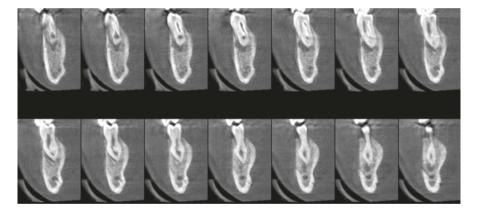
This is a small-field-of-view cone beam computed tomography scan of the first lefthand-side mandibular premolar which shows a dens invaginatus. It can be appreciated that there is already a periapical infection present and that the endodontic treatment will be complicated due to the complexity of the pulp system An attempt to classify dens invaginatus was first proposed by Hallett (1953). The first three types in Hallett's classification refer to crown invaginations. However, all crown invaginations were designated as type 1 in a classification system put forward by Oehlers (1957). Other classifications have also been described by Ulmansky and Hermel (1964), Schulze and Brand (1972), Vincent-Townend (1974), Parnell and Wilcox (1978), and Hicks and Flaitz (1985). The broad classification put forward by Schulze and Brand (1972) includes 12 variations, starting at the incisal edge of teeth, and therefore classifies malformations with respect to morphology of the invagination as well as the anatomic crown form and dysmorphic root configurations. However, the system described by Oehlers (1957) appears to be the most widely used, possibly because of its simple nomenclature and ease of application. The invagination varies in size and shape from a small dip in the enamel to a severe form, which looks like tooth within a tooth. The invagination frequently communicates with the oral cavity, allowing the entry of irritants and microorganisms either directly into pulpal tissues or into an area that is separated from pulpal tissues by only a thin layer of enamel and dentin. This continuous ingress of irritants and the subsequent inflammation usually lead to necrosis of the adjacent pulp tissue and then to periapical or periodontal abscesses. In many cases dens invaginatus and also dens evaginatus pose serious clinical and therapeutic problems. Endodontic treatment seems extremely difficult in a lot of cases and therefore a good long-term vision and plan are essential, which necessitates well-orchestrated collaboration between several dental specialties: pediatric dentist-orthodontistperiodontist—endodontist and perhaps even oral surgeon in some cases. Cone beam CT is the ideal imaging modality as it will clearly show the complexity of the pulpal system and its relationship with the periodontal surroundings of the tooth.
